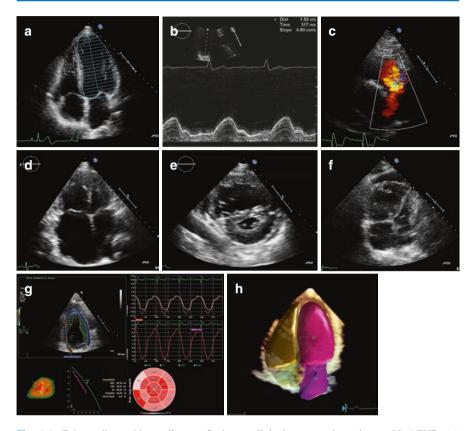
Echocardiographic predictors of adverse clinical outcome in patients with ACHD. (a) Measurement of left ventricular ejection fraction using the biplane method of disks (modified Simpson's rule) in a patient with aortic coarctation. (b) Mildly reduced TAPSE (<16 mm) in a patient with tetralogy of Fallot. (c) Severe pulmonary valve regurgitation visualized using color flow Doppler in a patient with tetralogy of Fallot. (d) Severe biatrial dilatation and (e) D-shaped left ventricle in a patient with pulmonary arterial hypertension after surgical repair of a sinus veno-sus defect and partial anomalous pulmonary venous return. (f) Pericardial effusion in a patient with pulmonary arterial hypertension. (g) Global longitudinal left ventricular strain as quantified with speckle tracking echocardiography (courtesy of R. W. J. van Grootel). (h) 3D echocardiography analyzed using automated software (heart model)
